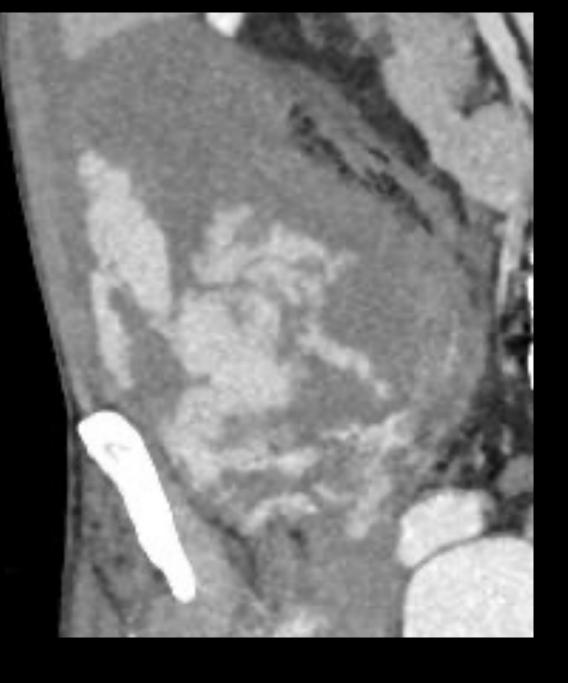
Ipsilateral femoral angiogram showing the arteriotomy at the level of the mid-head of femur. Figure 2B, 2C, 2D: Arterial phase CT showing access site hemorrhage with nonenhancing retroperitoneal hematoma. Figure 2E, 2F, 2G: Delayed phase CT showing enhancement extending into the inguinal canal and brisk enhancement of the retroperitoneal hematoma. This patient had a history of unspecified hernia surgery from an outside hospital.
